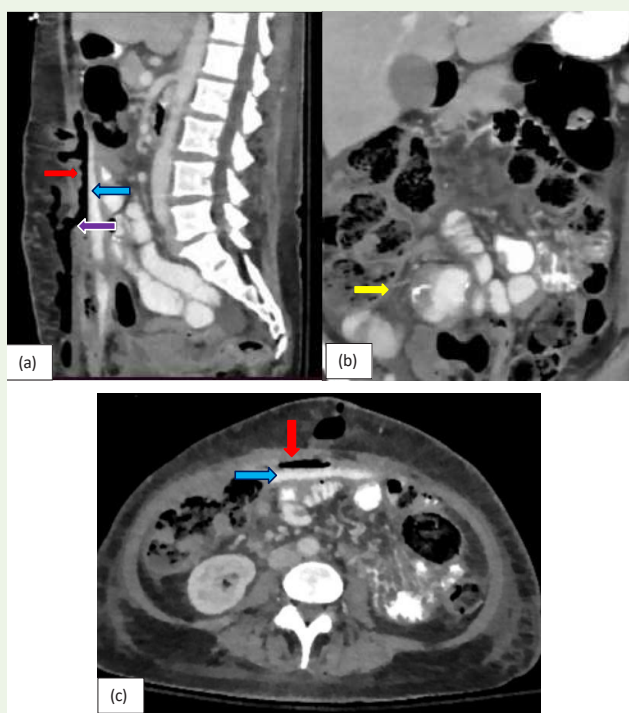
(a, b, c, d): Sagittal, Axial and coronal CT images of a 57-year-old male patient presents with lower abdominal pain. CT scan of abdomen and pelvis with oral and IV contrast shows extra-luminal extravasation of oral contrast adjacent to the ileocecal junction forming a focal collection with air fluid level in right lower quadrant of the abdomen (blue arrow), suggestive of anastomotic leak. Additionally, there is formation of another Extra-luminal collection with air-fluid level (purple arrow) is also seen in the pelvis suggestive of complications.
